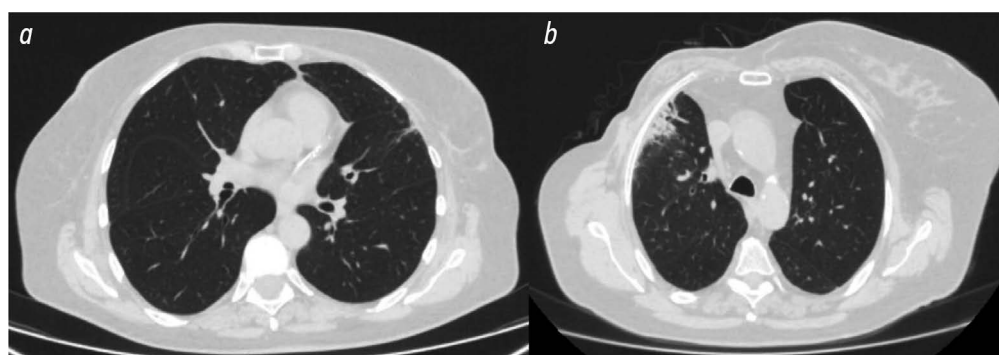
Chest computed tomography at 6 months postradiation therapy: *a*, minimal postradiation changes in the left lung; *b*, severe postradiation pneumofibrosis in the right lung.
